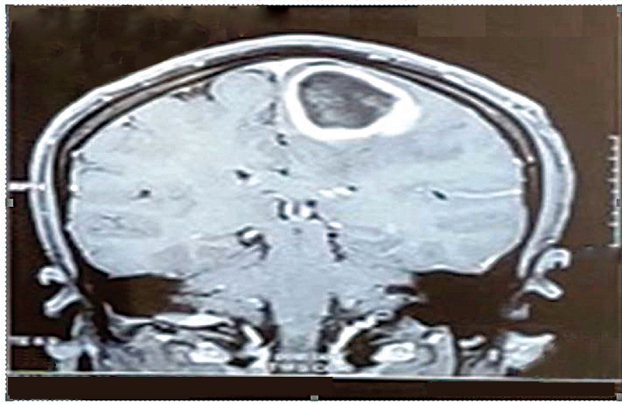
Gadolinium-enhanced T1-weighted magnetic resonance imaging of coronal section—well-defined, thick walled, $3.5 \times 4.0 \times 3.4$ cm ring-enhancing lesion within the left parasagittal frontoparietal region with perifocal vasogenic edema.
